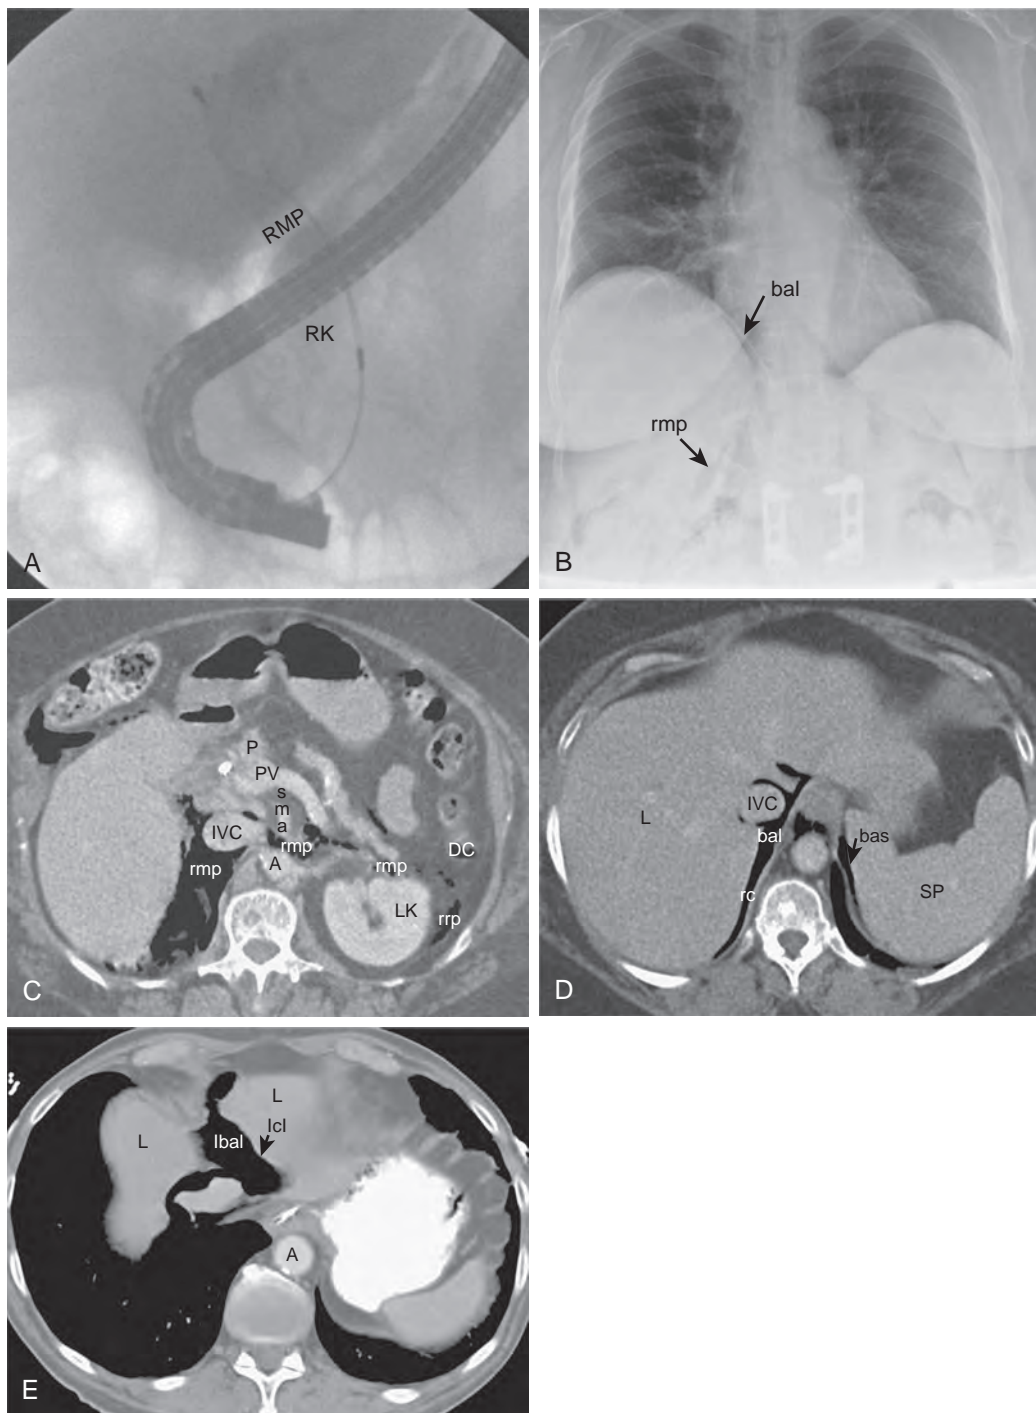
Superior extent of the intrafascial planes: right side. A. An oblique fluoroscopic image obtained during an interventional endoscopic procedure shows gas from a duodenal perforation outlining the retromesenteric plane (RMP) anterior to the right kidney (RK). B. The chest radiograph obtained immediately after the procedure shows a crescentic gas collection on the medial aspect of the right hemidiaphragm in the location of the bare area of the liver (bal). Gas in the retromesenteric plane (rmp) is discernible superior to the duodenal gas. C. CT section obtained in the same patient shows extensive gas filling the superior aspect of the retromesenteric plane (rmp). This gas continues anterior to the inferior vena cava (IVC) and extends to the left between the aorta (A) and superior mesenteric artery (sma) in the part of the retromesenteric plane created by fusion of the mesentery of the duodenum with the great vessels. This allows access of the right-sided plane to its counterpart on the left, anterior to the left kidney (LK) and behind the descending colon (DC). Some of the gas has dissected into the left retrorenal plane (rrp). P, Pancreas; PV, portal vein. D. The CT section obtained 4 cm superior to that in C shows gas outlining the bare area (bal) of the liver (L). The gas courses around the inferior vena cava (IVC) along the right diaphragmatic crus (rc). Some of the left-sided gas has ascended to the bare area (bas) of the spleen (SP). E. The CT section obtained 3 cm superior to that in D shows gas outlining the left portion of the bare area (lbal). This gas outlines the left coronary ligament (lcl), the edge of the peritoneal reflection of the left perihepatic spaces. L, Liver; A, aorta.
